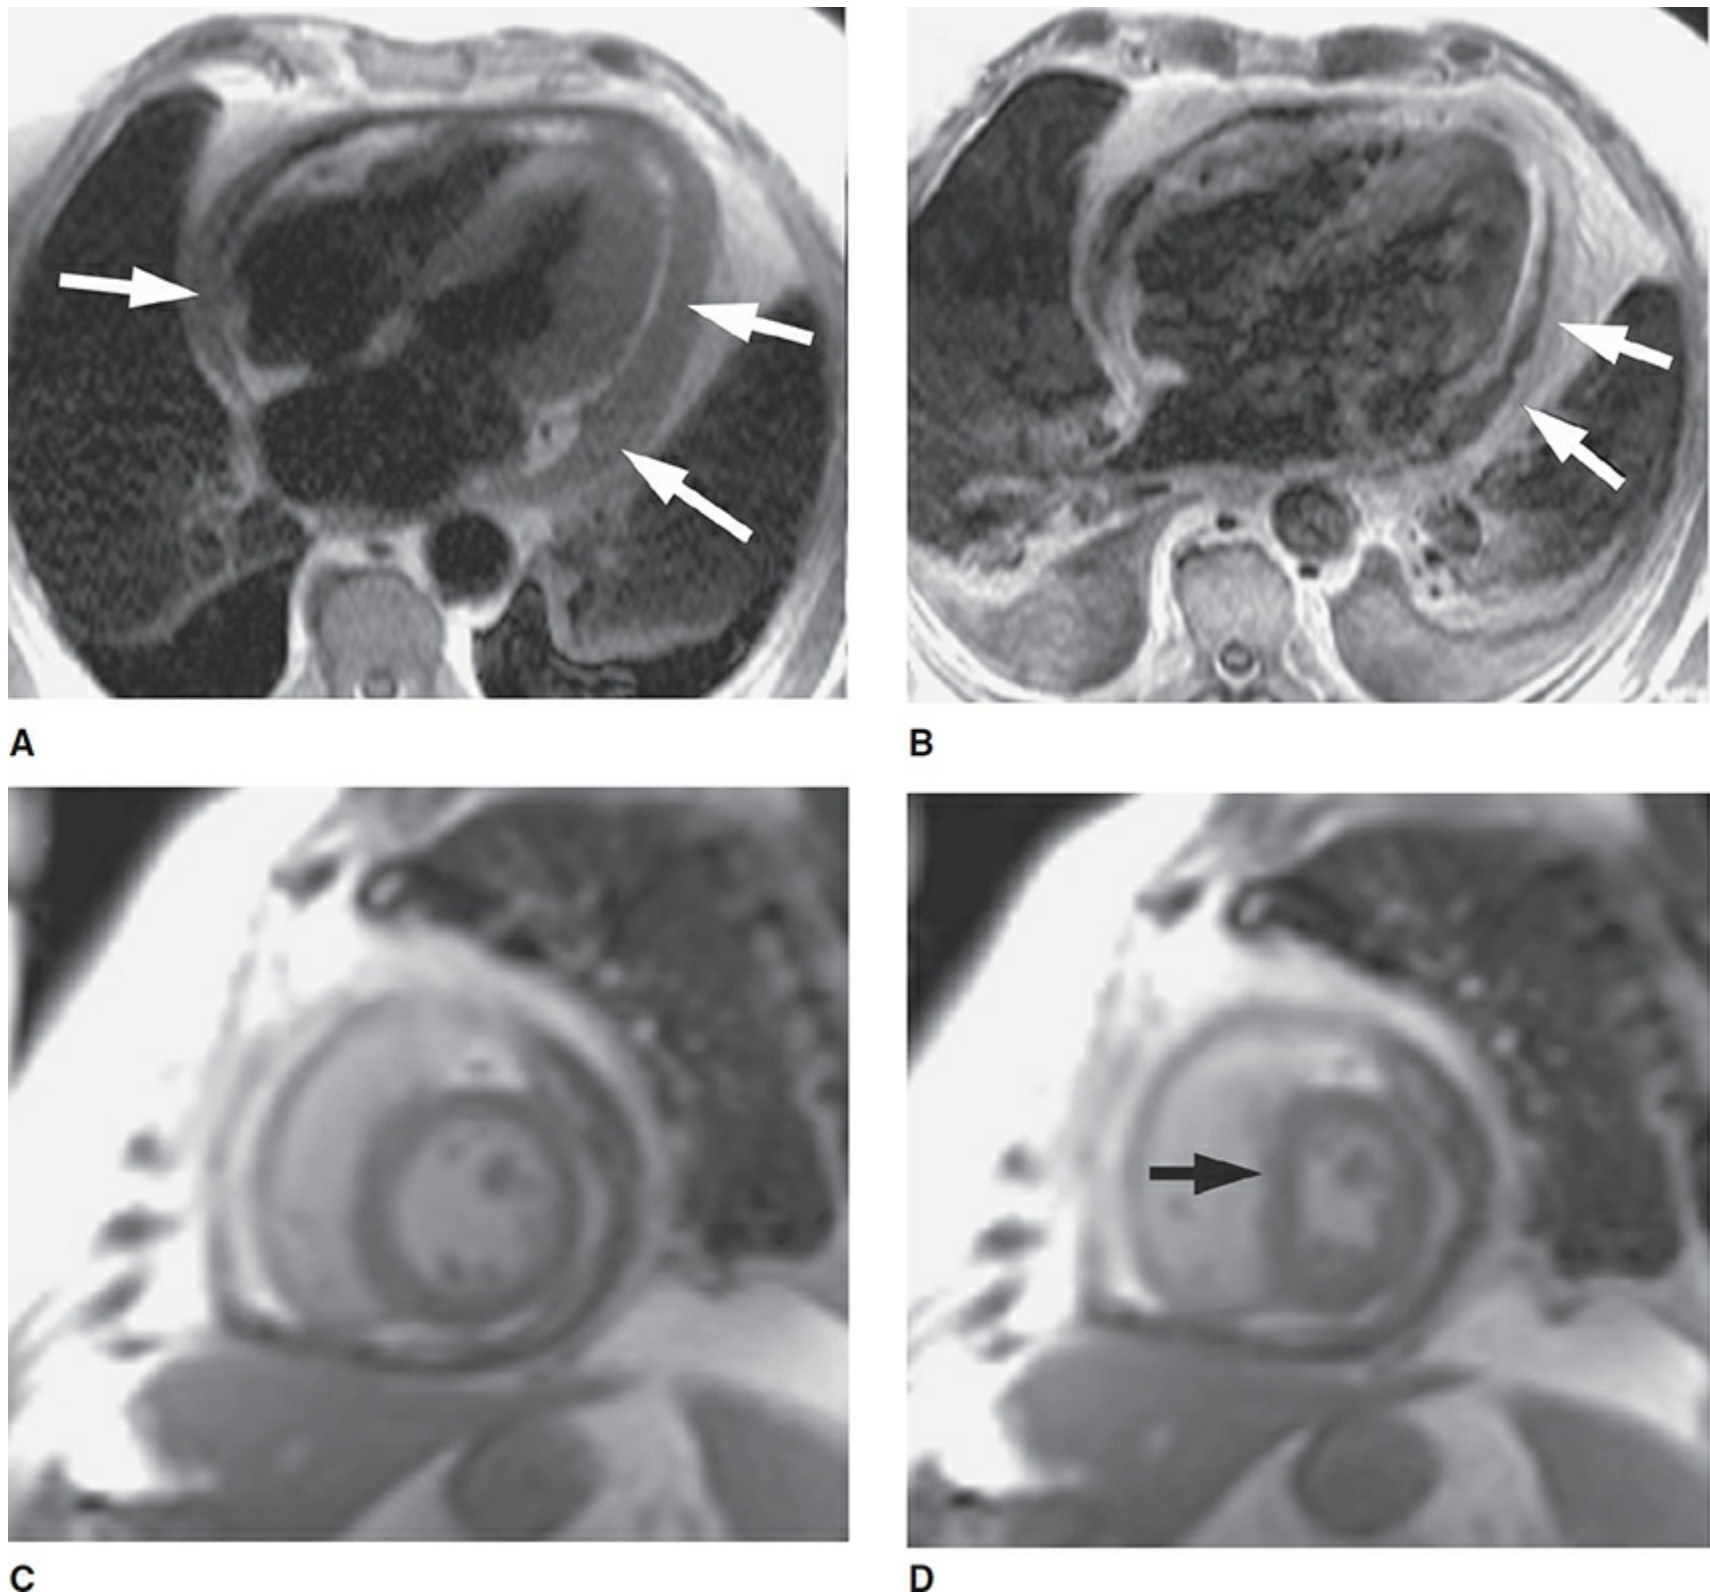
(A) Four-chamber T1-weighted spin echo demonstrating markedly increased pericardium (dark band, arrows). (B) Same image acquired after contrast showing pericardial enhancement (arrows). (C) and (D) Expiratory and inspiratory, respectively—diastolic short-axis frames from a real-time cine acquisition during free breathing. Note the marked septal flattening during inspiration (arrow) consistent with increased ventricular interdependence.
